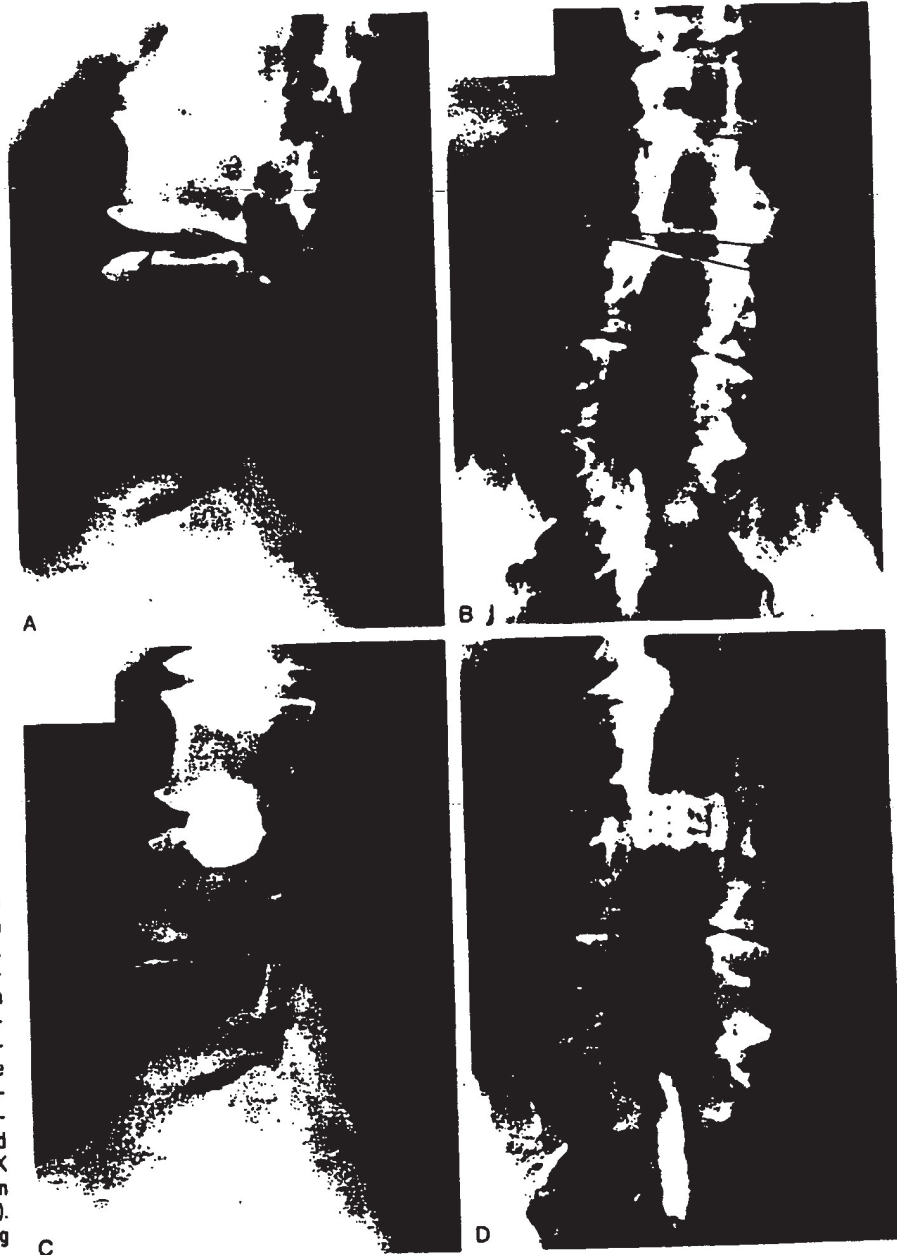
This 75-year-old man had back pain and right anterior thigh pain 2 years after he had undergone laminectomies from L3 to S1 with a posterolateral fusion from L4 to S1. The lateral (A) and anteroposterior (B) radiographs show "vacuum disk" sign at L3-L4 with lateral translation of the L3 vertebral body on L4. His characteristic pain was reproduced by an L3-L4 discogram performed by an independent radiologist. Lateral (C) and anteroposterior (D) radiographs were obtained after the procedure using the endoscopic retroperitoneal approach was performed and a transversely oriented BAK fusion cage was inserted (15 mm in diameter and 24 mm length). The patient's back and right leg pain resolved after surgery.
